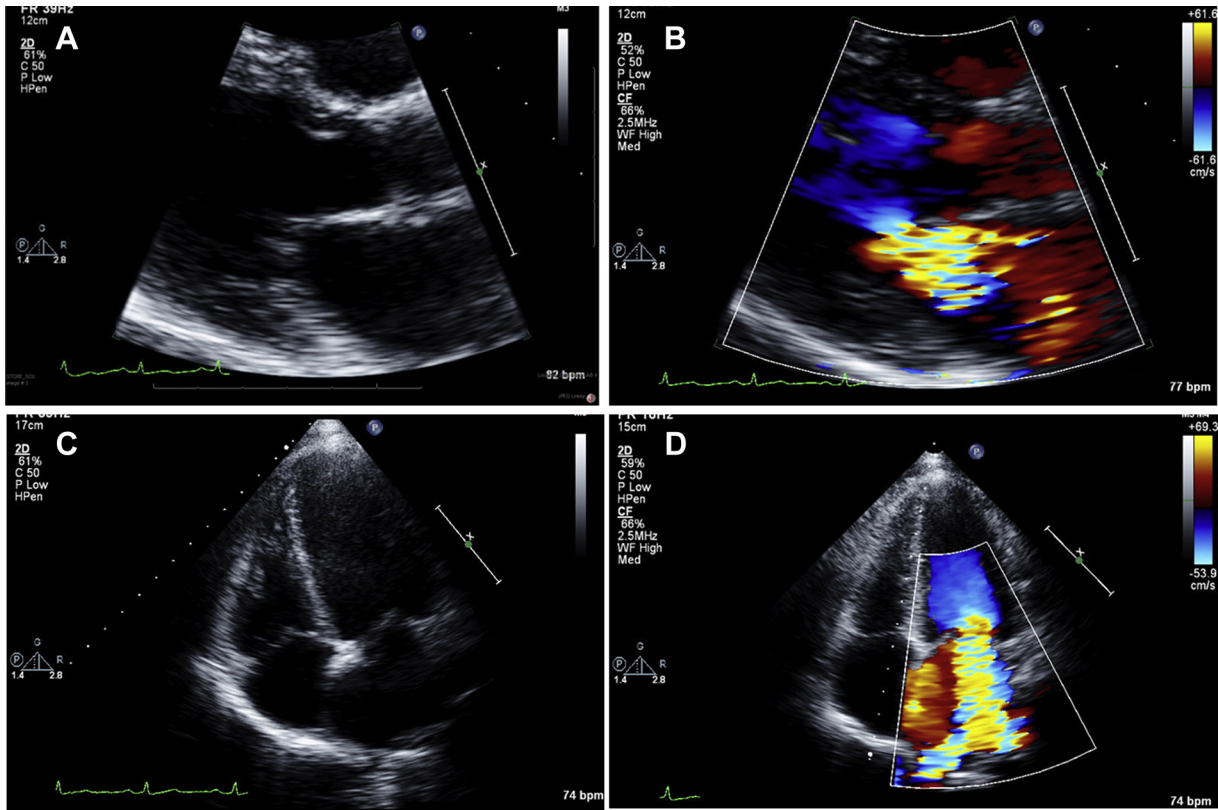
(A-D) Transthoracic echocardiogram (TTE), parasternal long-axis view without (A) and with color Doppler (B), showing severe mitral regurgitation. TTE apical four-chamber view (C-D) again showing severe mitral regurgitation.
